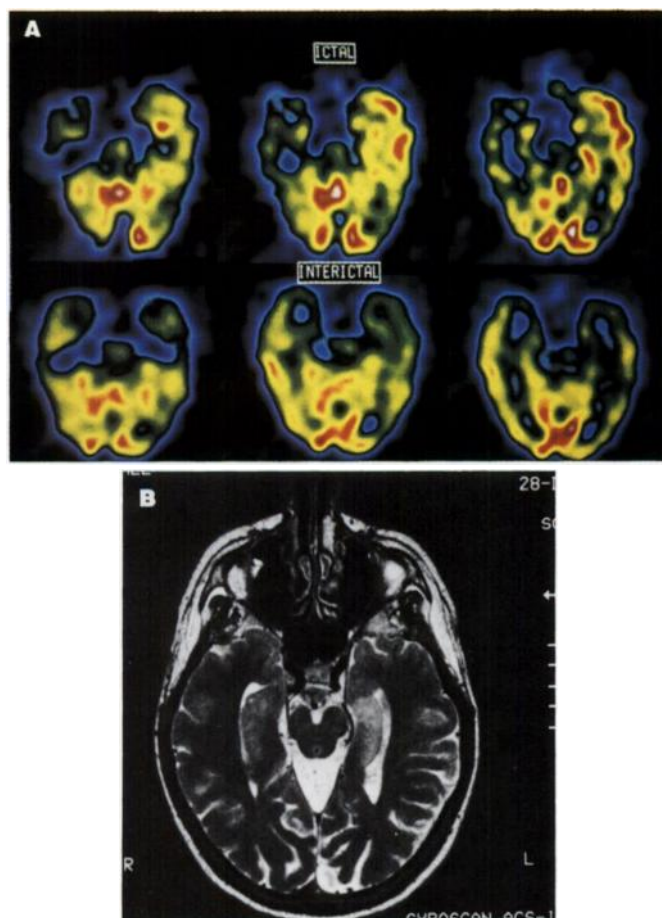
Interictal and ictal perfusion pattern in a 38-yr-old woman with bilateral EEG foci and suspected left temporal lobe sclerosis (Patient 9). The ^{99m}Tc -ECD-SPECT (A) (slices angulated parallel to the long-axis of the temporal lobes) shows decreased perfusion of the left temporal lobe interictally and markedly increased perfusion in the left temporolateral and temporopolar region and also a slightly increased perfusion in the mesial structures during the seizure. The MRI scan (B) (T2-weighted TSE-sequence, temporal angulation, slice thickness 2 mm/0.2 mm) shows an increased signal within the left hippocampus (typical sign of hippocampal sclerosis).
